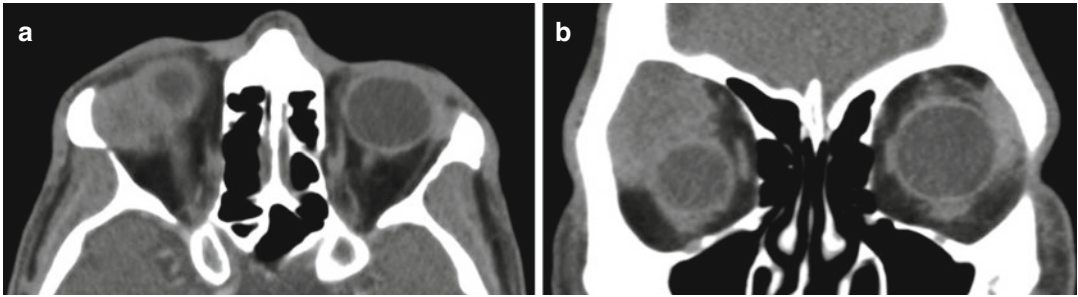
Adenoid cystic carcinoma; a 59-year-old male presented with upper eyelid ptosis, mild proptosis, and limitation of upgaze on the right. (a, b) CT shows a right lacrimal gland mass that appeared to depress the globe and erode adjacent bone. Fine-needle aspiration biopsy revealed small basaloid tumor cell clusters within entrapped stroma consistent with adenoid cystic carcinoma.
